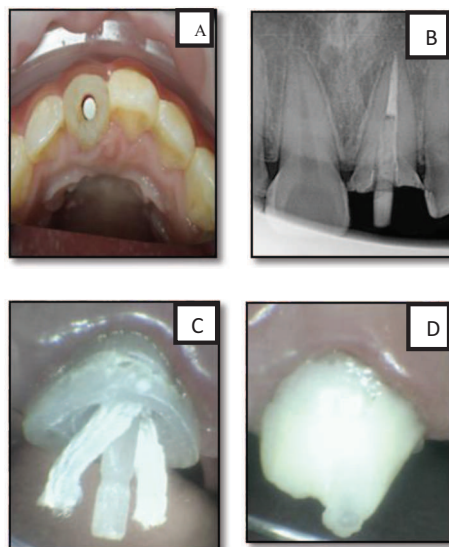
(A) Prefabricated post placement (B) Radiography of prefabricated post placement (C) Prefabricated fiber post and Polyethylene ribbond seated into wide canal (D) custom post and core
